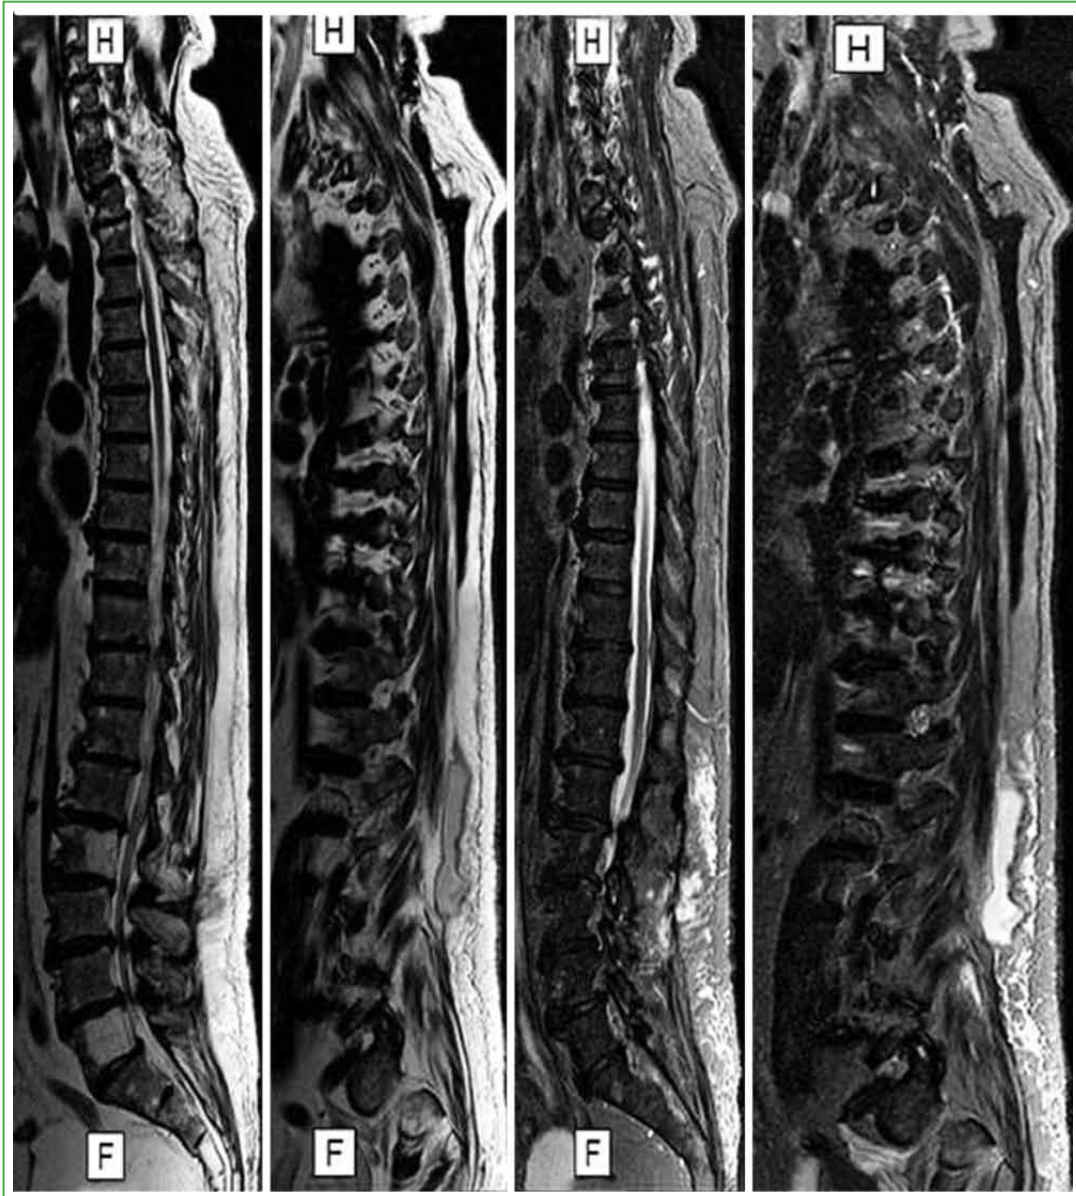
Sagittal view of T1-weighted, T2-weighted and STIR MRI scans of the entire spine showing a hyperintense fluid collection at the level of the right paraspinal muscles.
